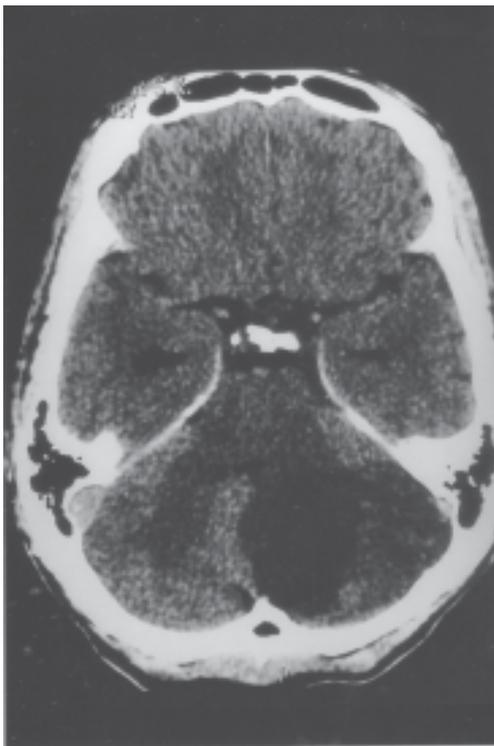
Non-contrast CT scan of brain with a low attenuation area in the left cerebellar hemisphere suggestive of an acute infarction.
